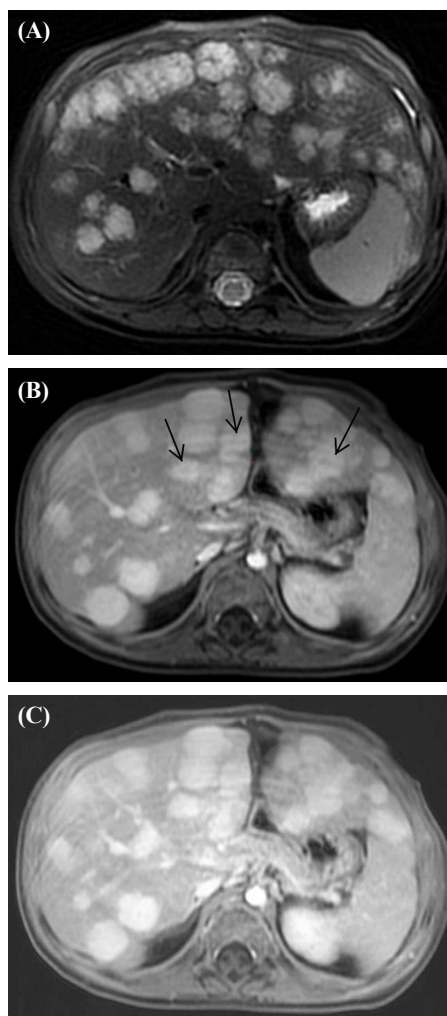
Follow-up T2-weighted axial MR image obtained after 9 months of therapy shows marked reduction number and size of lesions (A); after gadolinium contrast injection, there is peripheral enhancement in the arterial phase (B); and homogenous enhancement in the late phase (C).
